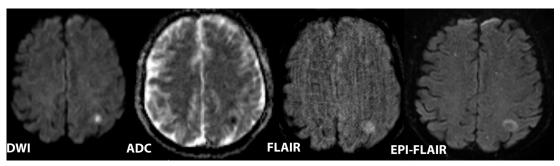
A 28-year-old man with past medical history of intravenous drug abuse and infective endocarditis presented with right-sided weakness 6 hours before imaging. Baseline NIHSS: 5. The patient was uncooperative and could not hold still. There is an acute infarction in the left postcentral gyrus with associated FLAIR hyperintensity, presumably caused by septic embolism in this patient who had positive blood culture (methicillin-resistant *Staphylococcus aureus*) and positive echocardiography with vegetations. Note the significantly better image quality on EPI-FLAIR image compared with conventional FLAIR, which is degraded by motion artifact. This difference is a clear advantage of the EPI-FLAIR technique used in our 6-minute MR stroke protocol because of the shorter acquisition time (52 seconds in EPI-FLAIR compared with 3 minutes in conventional FLAIR), in particular in uncooperative patients.
